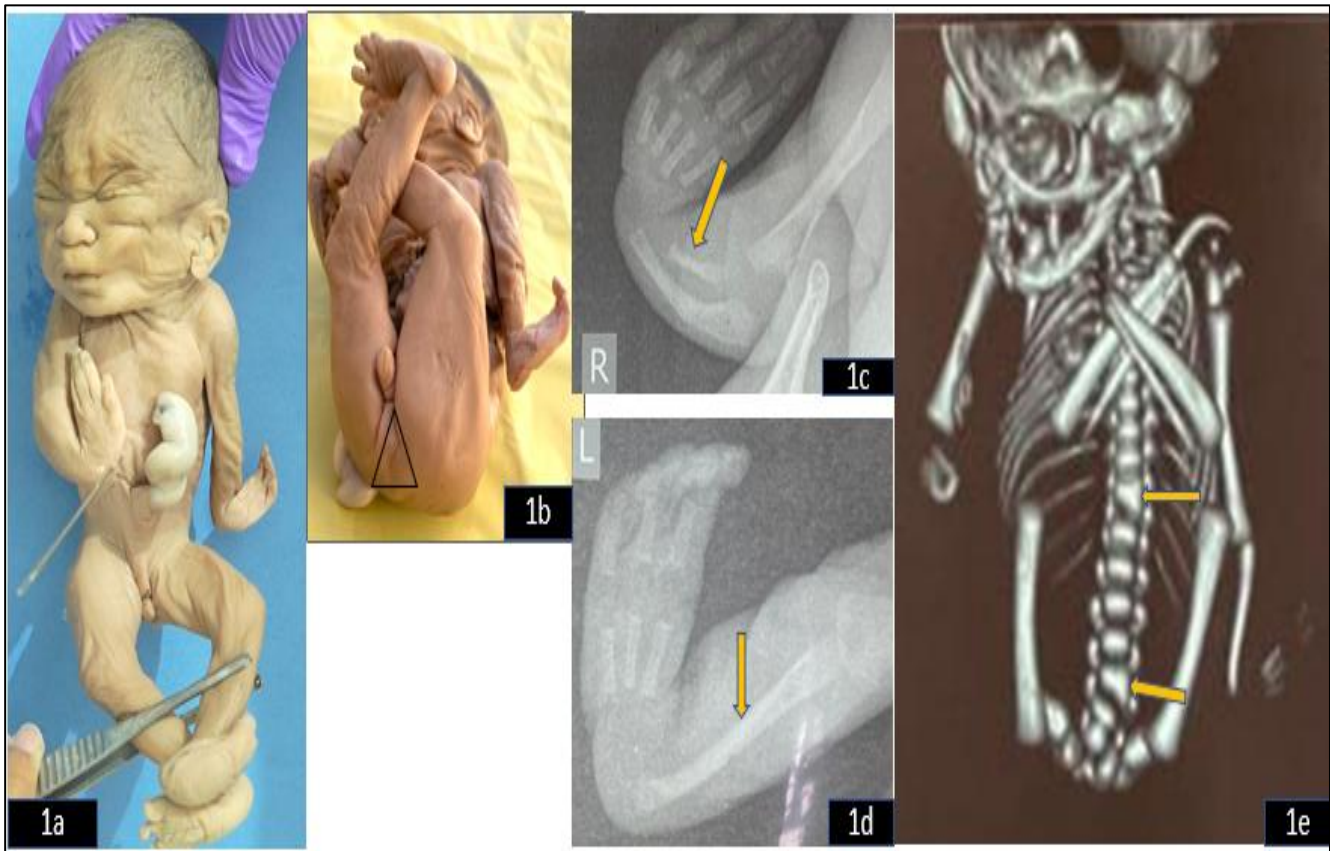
(a-e): Gross and radiological examination of (a) case 1; (b) imperforated anal orifice, (c) short radius, right, (d) isolated left ulna, (e) CT image showing Wedge shape vertebrae.
